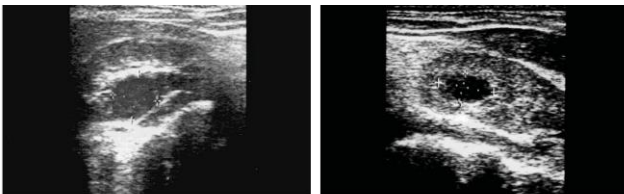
Ultrasonograms of kidney in "gray scale":
